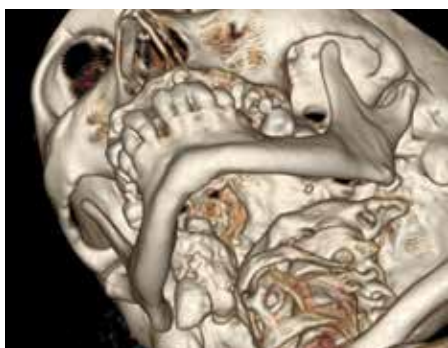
Case 2: A 3D-CT showing a multi-lobulated mass on the right side of the neck extending from infra-auricular region to 2 cm above clavicle.
